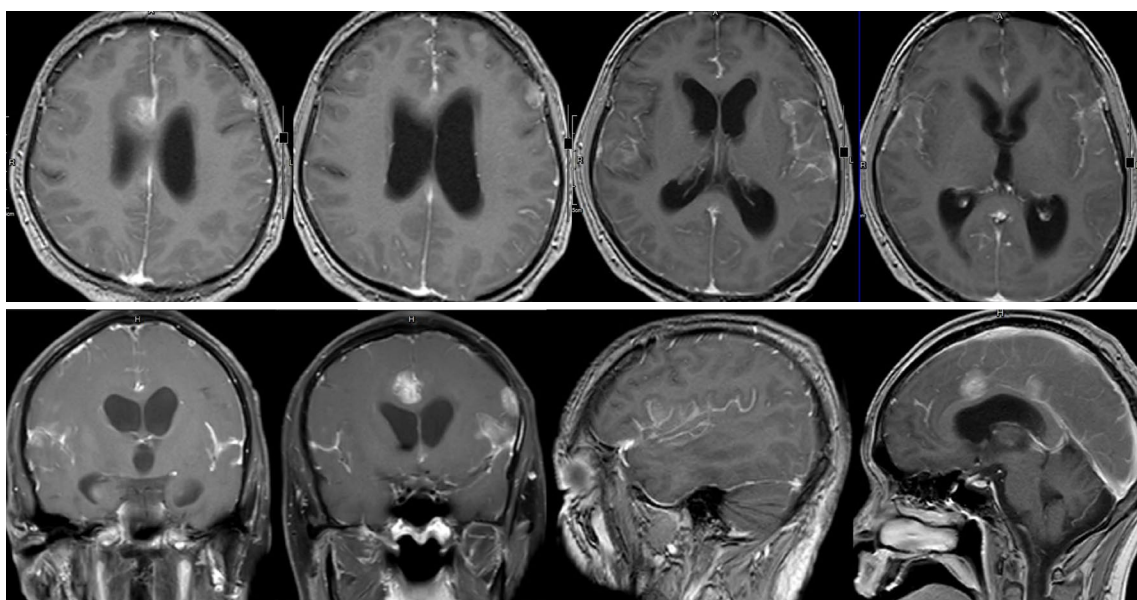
MRI of the leptomeningeal metastasis, hydrocephalus and multiple brain metastasis (T1 weighted contrast enhancement images).
